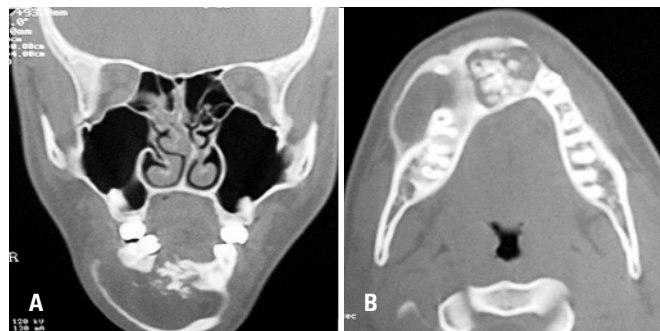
(A) Axial computed tomography scan showing a hypodense lesion associated with calcified deposits inside the lesion. (B) Coronal computed tomography scan showing hypodense lesion and calcified deposits surrounding the alveolar crest
